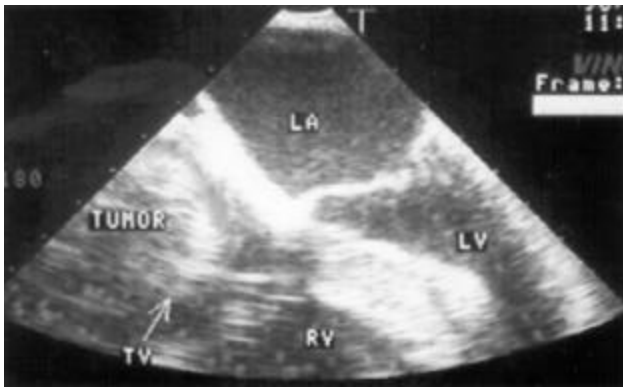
2D-doppler echocardiography before atrial tumor resection.
